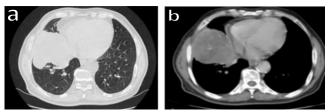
Thoracic CT scan in parenchymal (a) and mediastinal (b) windows showing a middle lobar tumour mass with regular thickening of the pleural sheets opposite
